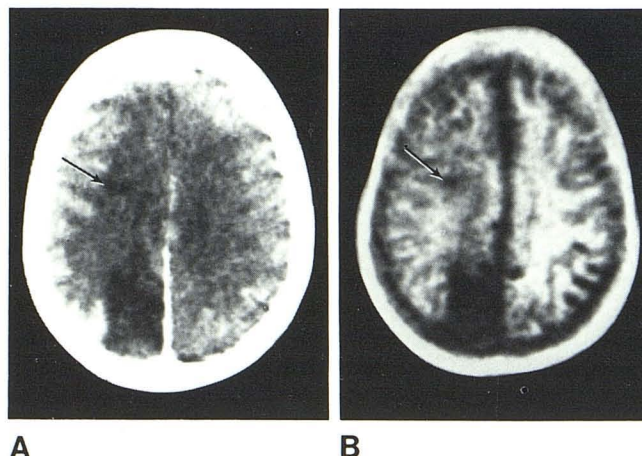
Acute infarction. A, Contrast-enhanced CT. B, IR_{1400/400}. Infarct in occipital region seen on both scans. Possible small area of infarction (arrows) and some loss of gray-white matter contrast in left hemisphere (B).
